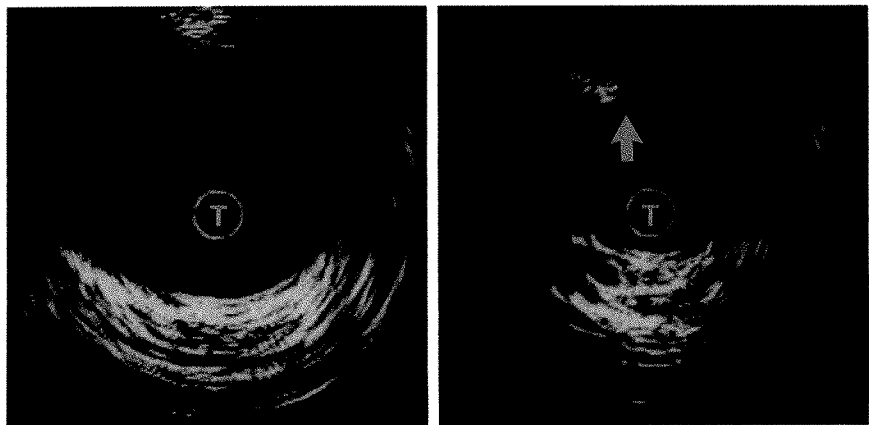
A, Cross-sectional sonogram of urine-filled bladder. Initial image without compression of anterior wall.
